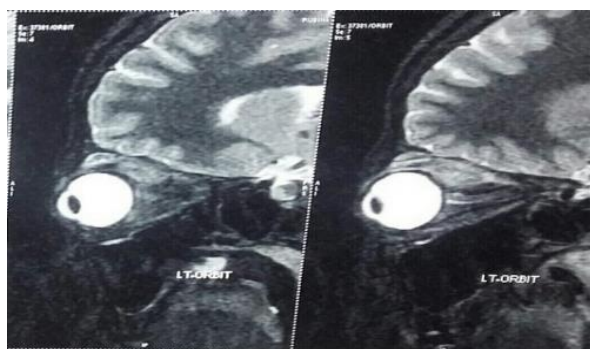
Sagittal T1-weighted MRI scans showing abscess with surrounding edema in left superior rectus
